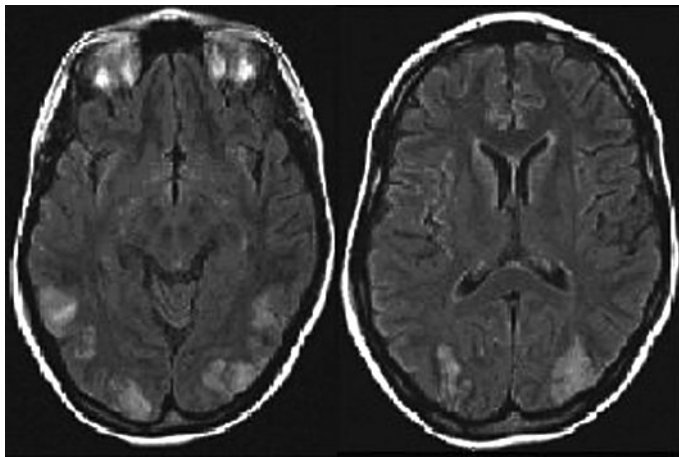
Brain MRI showing the subcortical edema in the occipital and temporal lobes.
